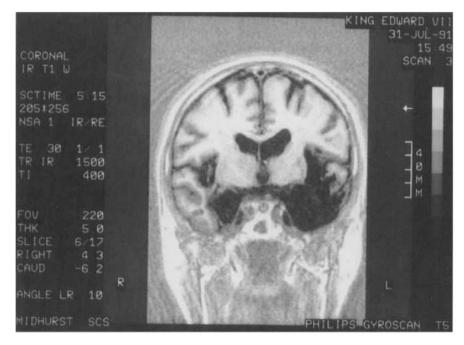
Coronal view of MRI scan of C's brain, showing the lesions (Wilson et al., 1995).
